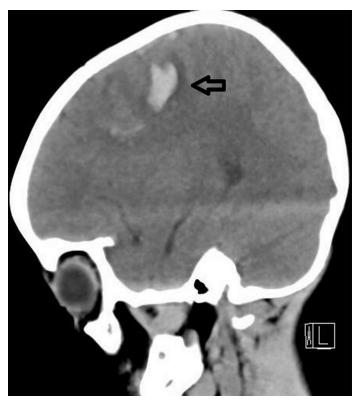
CT impression of the patient showing multiple foci of parenchymal hemorrhage in the left parietal lobe.
